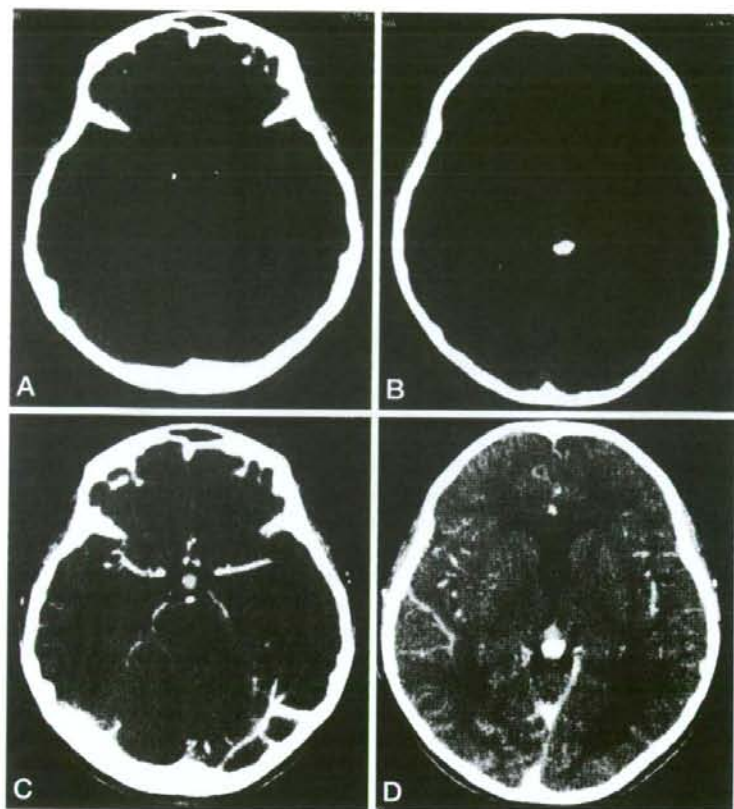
Plain (A, B) and enhanced (C, D) CT findings: Plain CT demonstrates isodense masses in the suprasellar and pineal regions, and enhanced CT shows homogenous enhancement of these masses.
